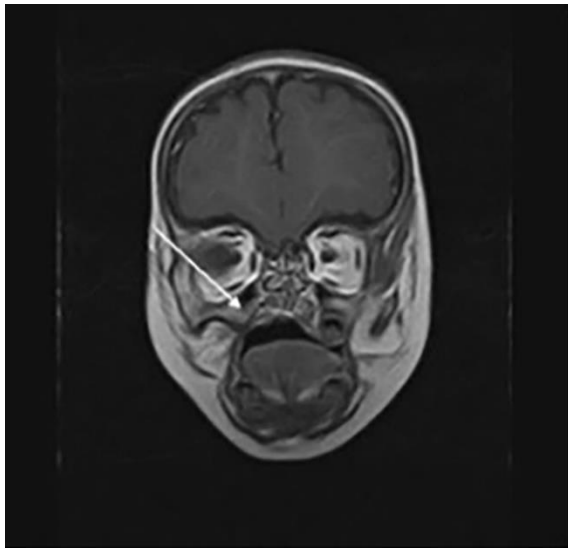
One-year postoperative follow-up head and neck MRI evidencing complete resolution of the tumor.
